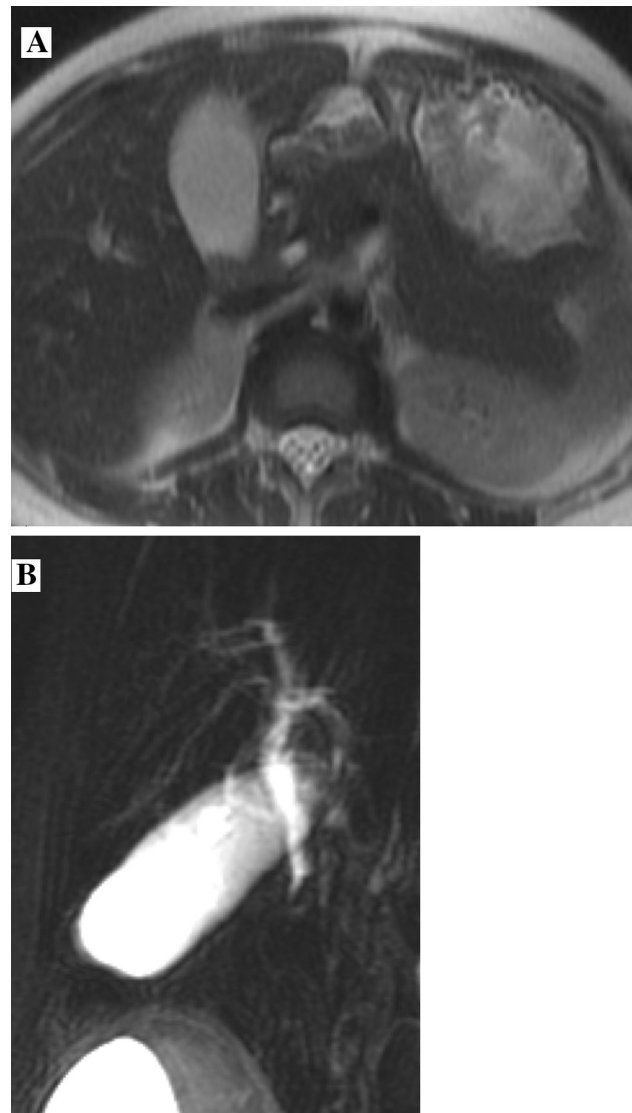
32-year-old, 27-week pregnant woman with right upper quadrant pain. Initial sonography demonstrated cholelithiasis (not shown). Axial single-shot fast-spin echo image (a) demonstrates multiple small dependent calculi in the gallbladder. MRCP image (b) shows a distal common bile duct calculus (arrow) with mild dilatation of the common bile duct, but no evidence of a common duct calculus
